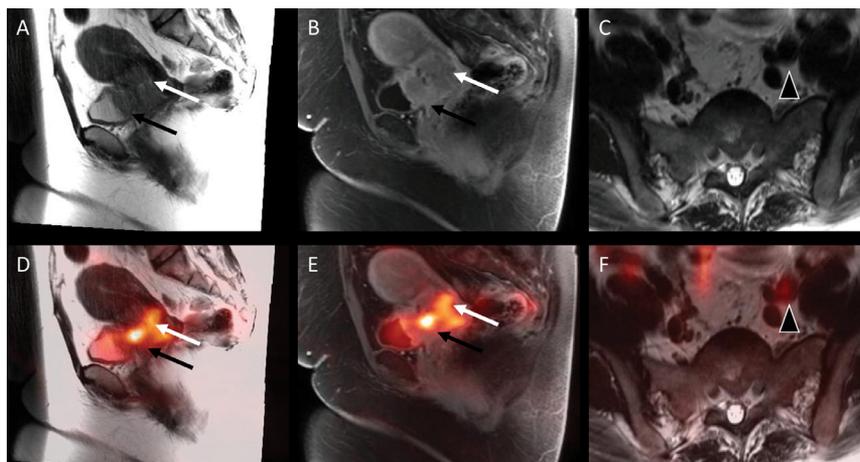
Cervical cancer. Pelvic MR (upper) and fused ⁶⁴Cu-ATSM-PET and MR images (lower). Sagittal T2-weighted (A), sagittal T1-weighted postcontrast (B) and transaxial T2-weighted (C) images. Fused ⁶⁴Cu-ATSM-PET with same sequences MR images (D-F) in a 33-year-old woman with newly diagnosed squamous cell carcinoma of the cervix. The images demonstrate a ⁶⁴Cu-ATSM avid mass centered within the anterior cervix, which extends to and involves the lower third of the uterine body (white arrows) invading the posterior bladder wall by the mass (black arrows). Avid lymphadenopathy is also noted (arrow heads).
